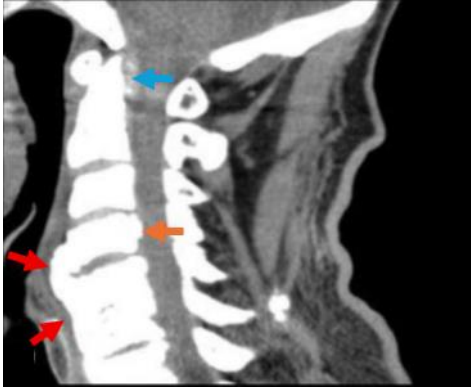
Case 4 (Inflammatory Discitis) - Sagittal cervical CT scan revealing C4-C5 and C5-C6 discitis with prominent osteophytosis (red arrows), calcification of the periodontal (blue arrow) and posterior longitudinal ligaments (orange arrow).
